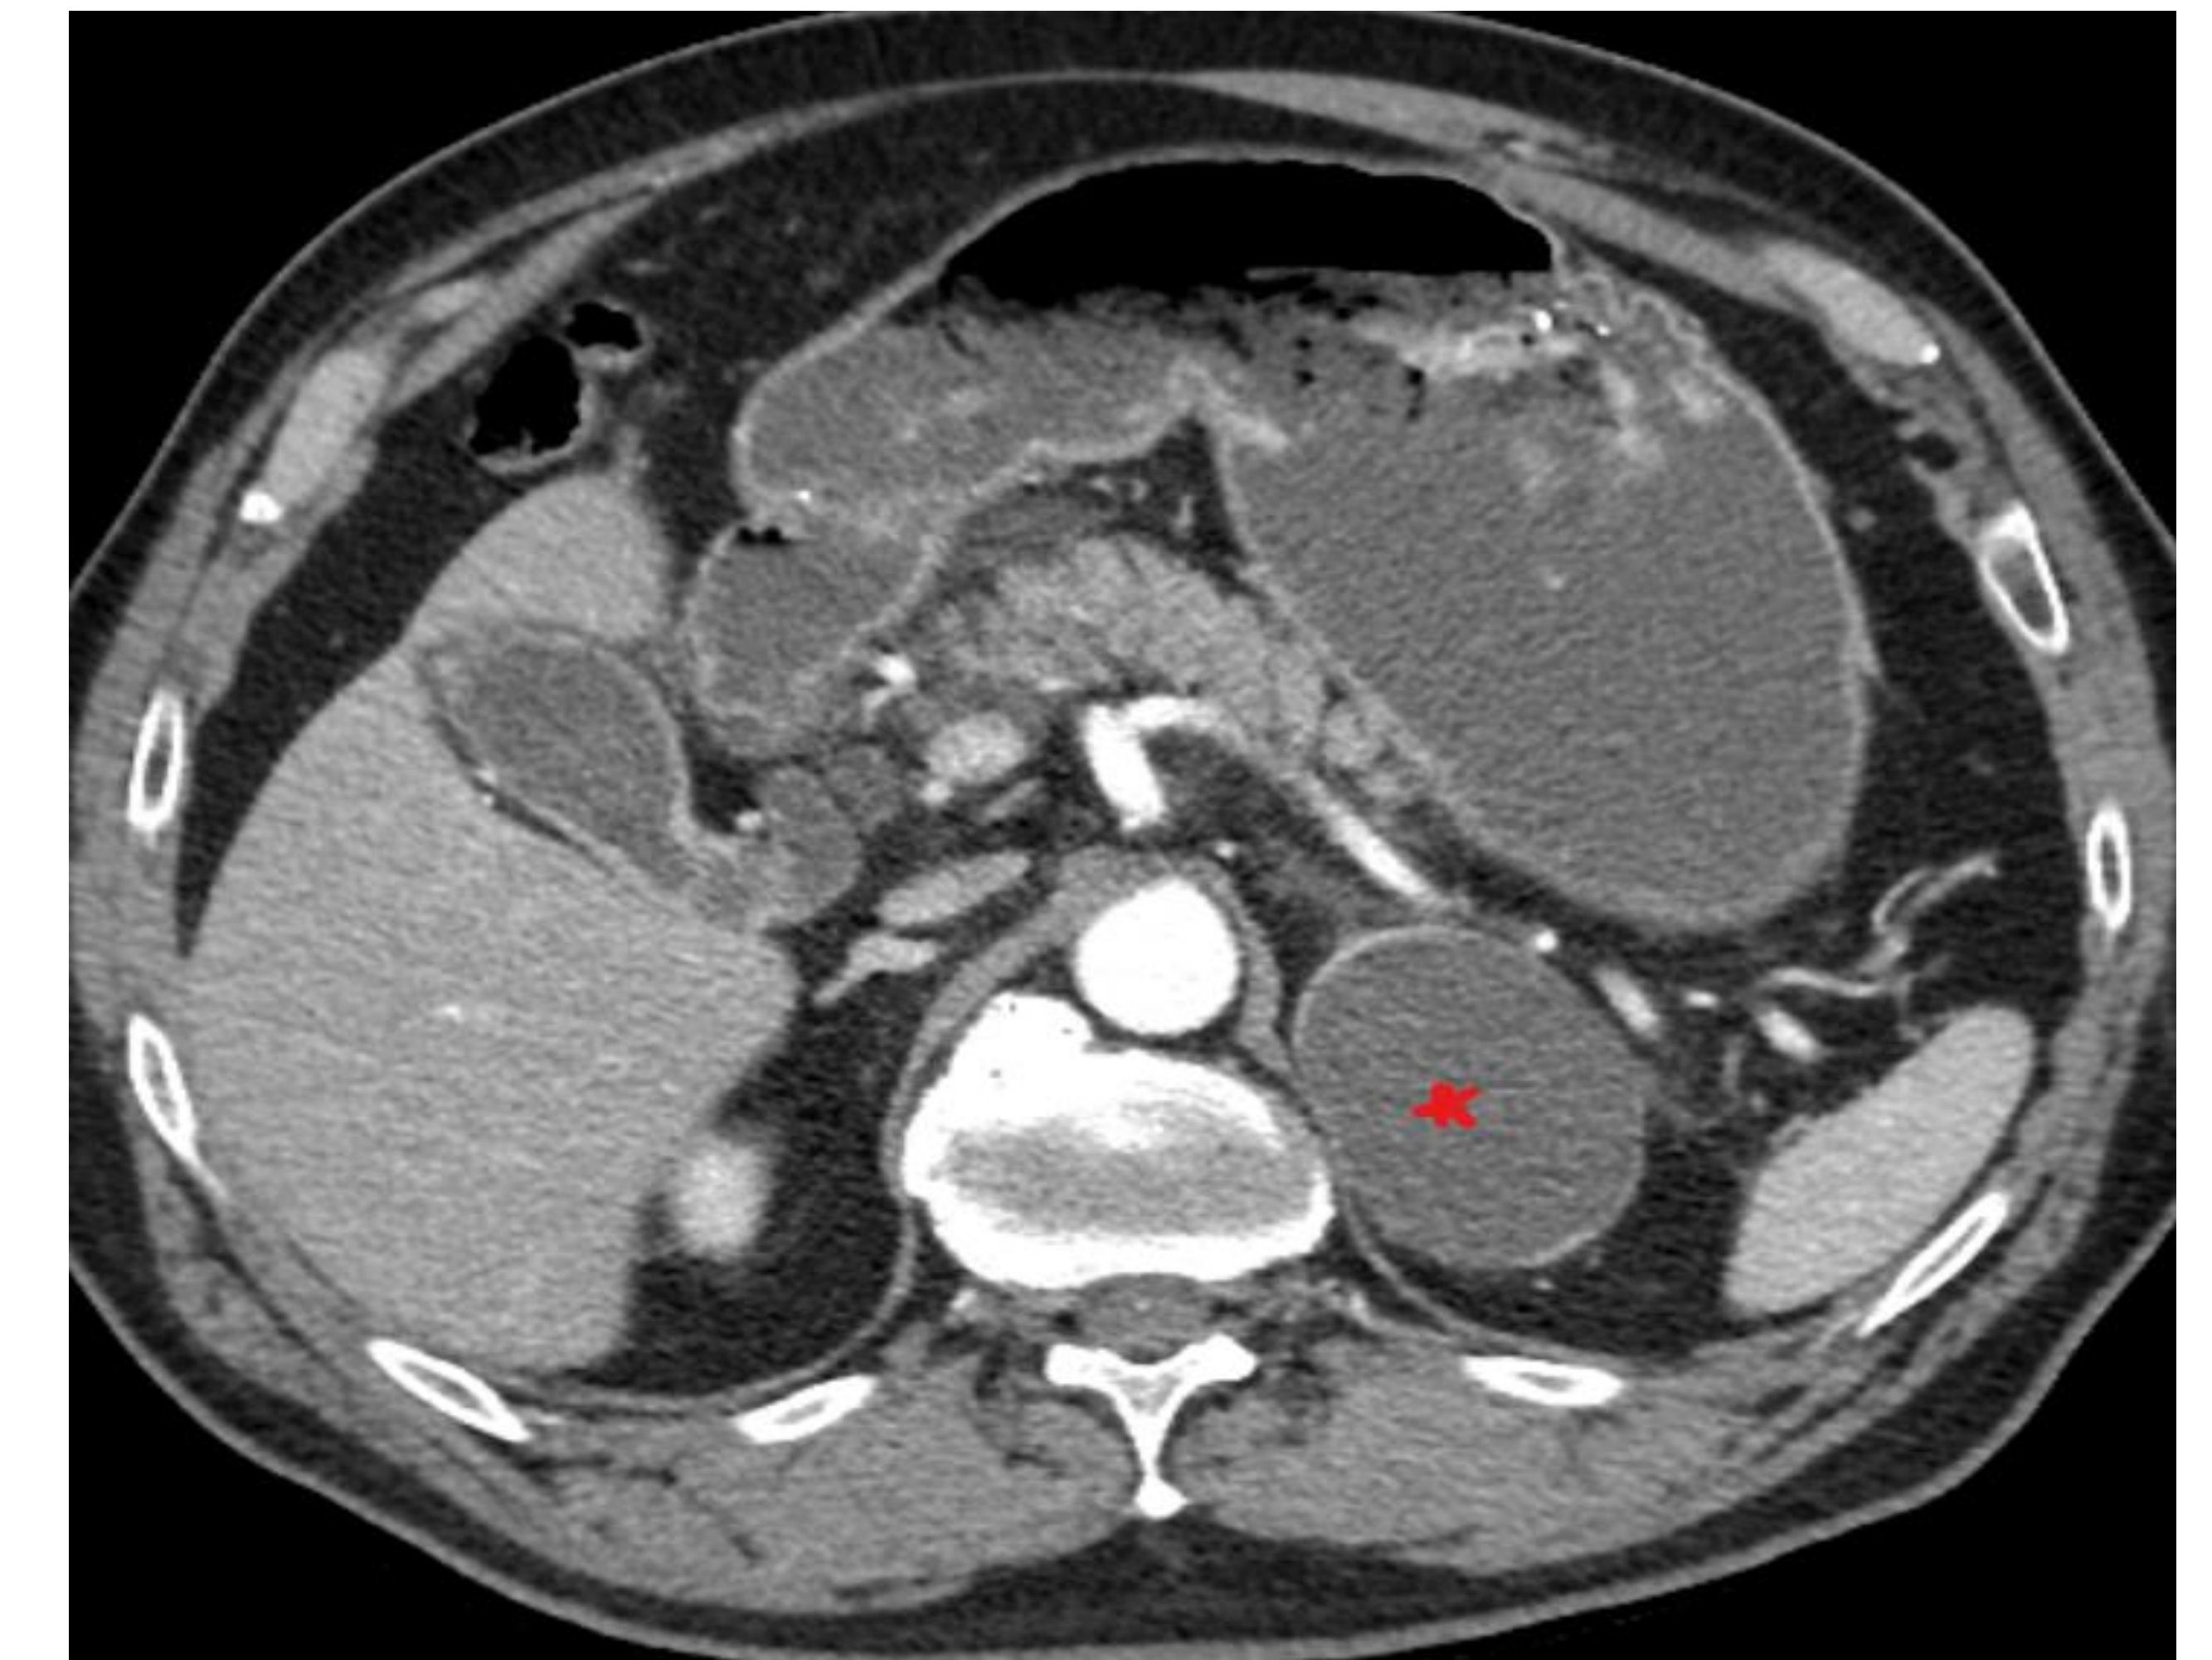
CT scan demonstrating 6.6 cm left adrenal adenoma.
